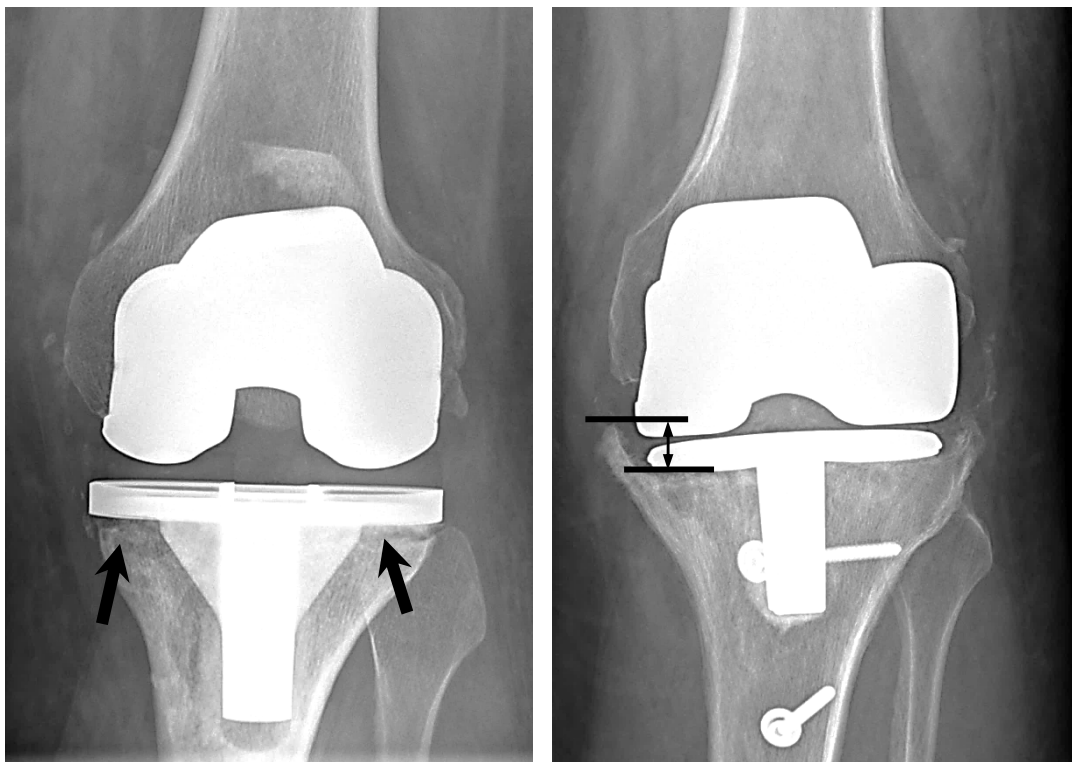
Radiographic scans showing signs of loosening. Left: Aseptic loosening with radiolucent lines and osteolytic zones below the tibial plateau (arrows); low-grade infection is possible. Right: Septic loosening with migration of the tibial and femoral component. Measure indicates original and current position of the tibial tray. [Scans provided by University Hospital Heidelberg]
